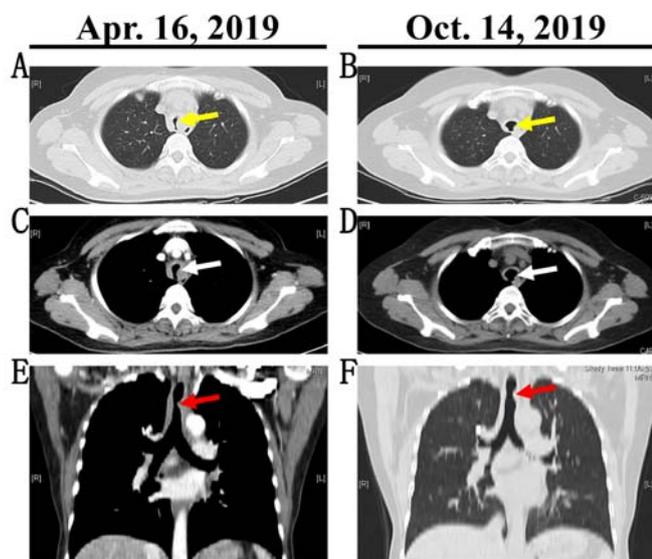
Thoracic CT images. (A) Severely MTS before treatment and (B) substantial alleviation of MTS after treatment in view of lung window; yellow arrow. (C and D) Corresponding images in the mediastinal window to (A) and (B) respectively. (C) Obstruction before therapy and (D) changes after therapy in mediastinal window. (E) Chest CT by three-dimensional reconstructing revealed changes of MTS before therapy and (F) after therapy from the coronal plane, red arrow. MTS, main tract stenosis.
